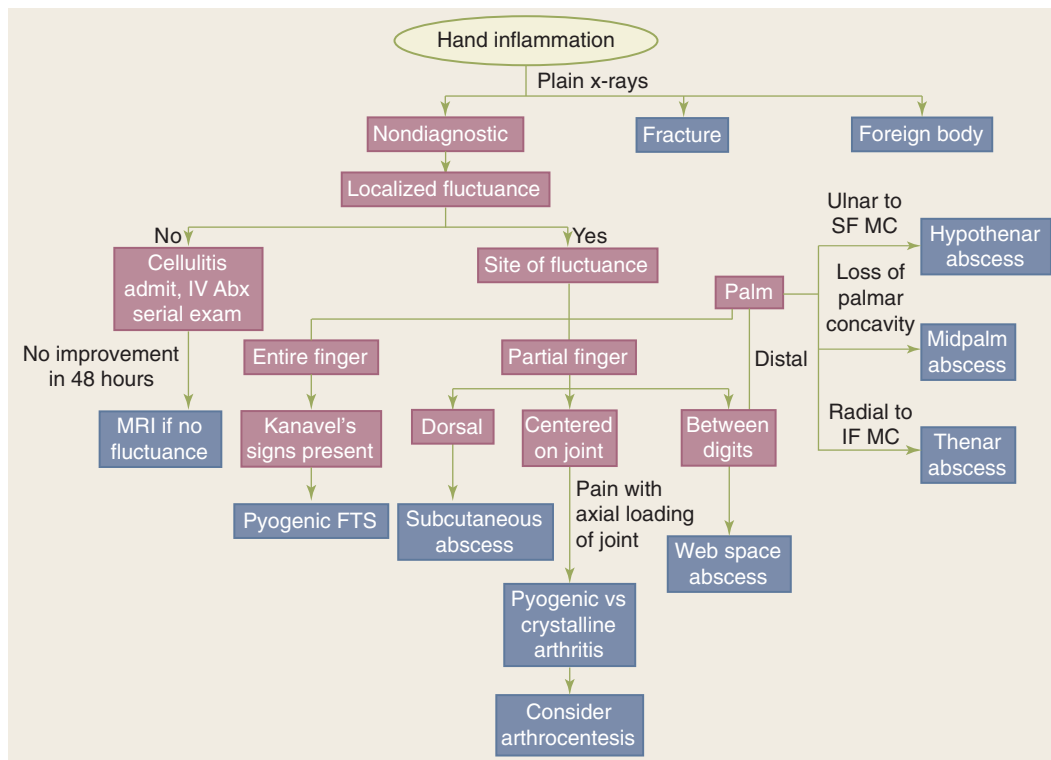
Diagnostic algorithm. Diagnostic workup for a patient with hand inflammation to evaluate for infection. See text for details about particular infectious diagnoses. Abx = antibiotics; FTS = flexor tenosynovitis; IF MC = index finger metacarpal; MRI = magnetic resonance imaging; SF MC = small finger metacarpal.
